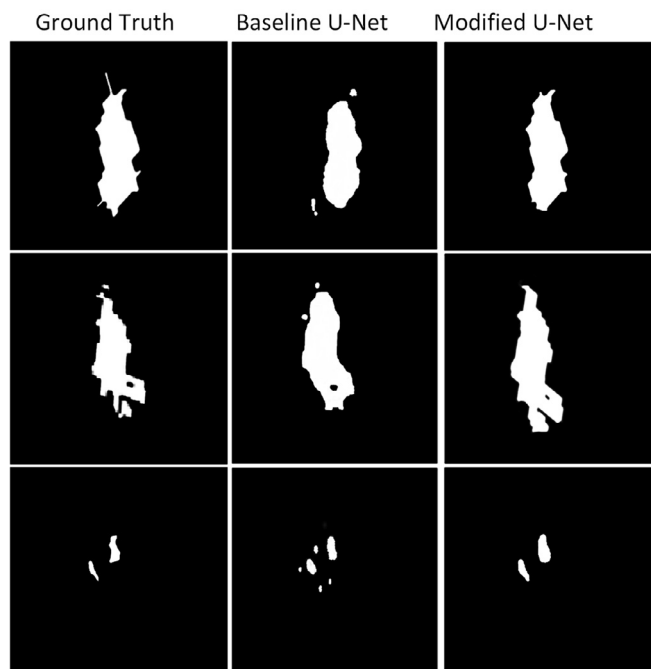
Comparative results of baseline and modified U-Net on three MRI scans (results are zoomed out for clear demonstration).
